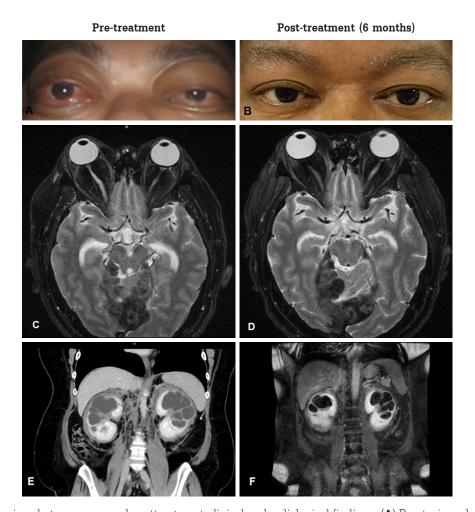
Comparison between pre- and posttreatment clinical and radiological findings: (A) Proptosis and chemosis were initially present before treatment; (B) Ophthalmic symptoms improved and dry skin was noted after six months of treatment; (C) Pretreatment MRI brain and orbits showed multiple lobulated extra-axial masses and pressure effect of the lesions causing bilateral optic nerves atrophy (more severe on the right), obstructive hydrocephalus; (D) Posttreatment MRI brain and orbits presented decreased degree of obstructive hydrocephalus without significant interval change in the size of the bilateral orbital and multiple extra-axial masses; (E) Pre-treatment CT abdomen manifested a symmetrical infiltrative soft tissue lesion involving bilateral intrathoracic paravertebral, para-aortic, perinephric and suprarenal regions and markedly diffuse dilatation of bilateral pelvicalyceal systems with thinning of renal cortex in both kidneys; (F) Posttreatment MRI abdomen showed the stability of infiltrative soft tissue lesions involving bilateral perinephric regions and retroperitoneal space, besides, the marked dilatation of bilateral pelvocalyceal systems with thinning of renal cortex remains unchanged.
